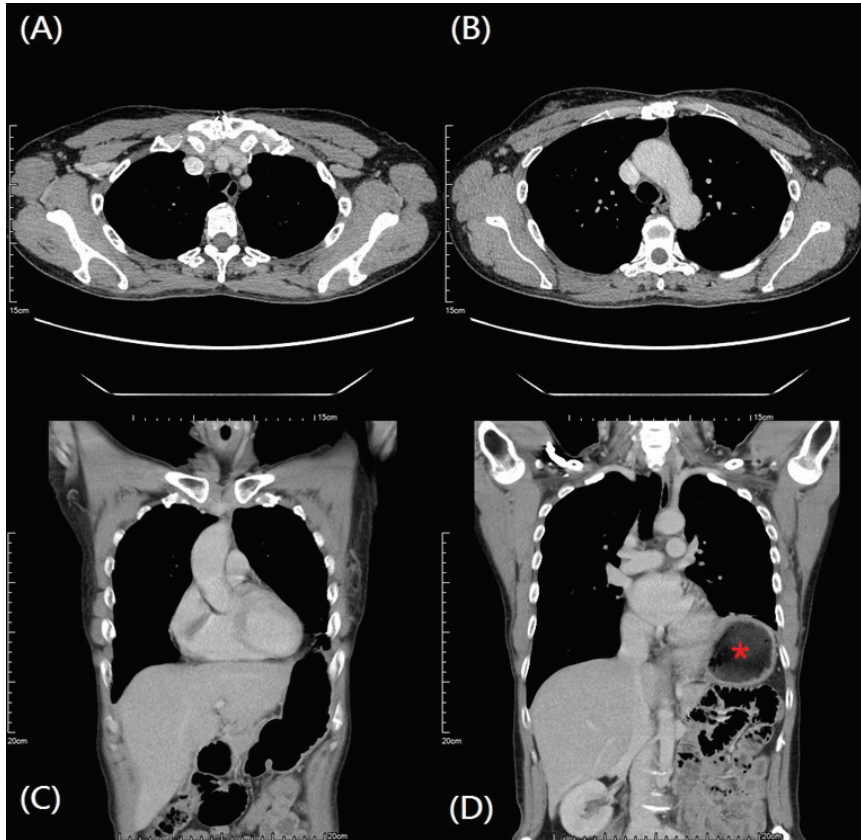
CT at 4 months after surgery, (A)(B) axial view, and (C)(D) coronal view, showed no local recurrence, but revealed left diaphragm eventration (Red star: stomach).
